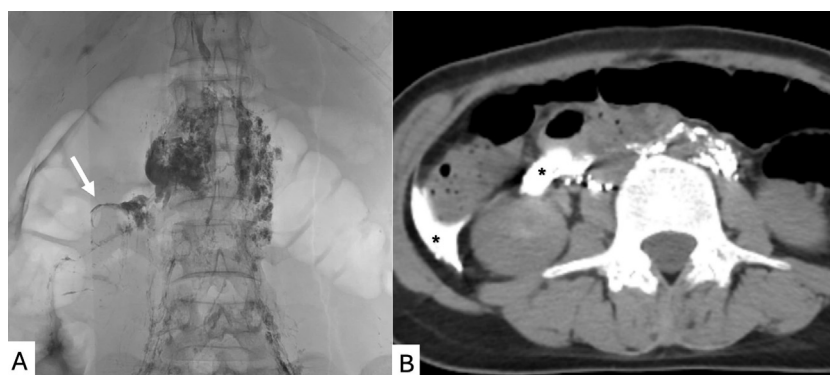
(A) The imaging from fluoroscopy confirmed extravasation of contrast from a right-sided thoracic duct branch (white arrow). (B) Cone-beam CT imaging confirmed the presence of contrast in the abdominal cavity (black asterisk).
